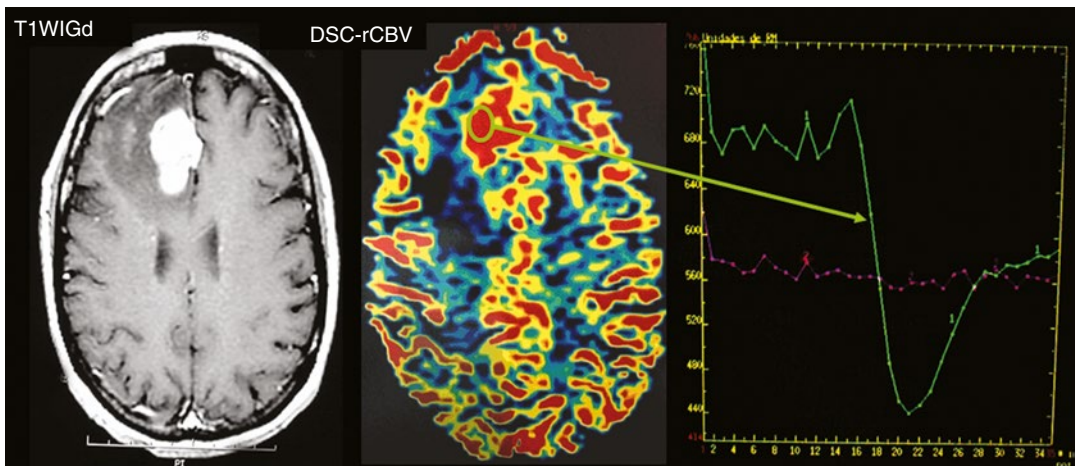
A 52-year-old woman with oligodendroglioma. An expansive-enhancing right frontal lesion with high perfusion (increased rCBV on DSC-MRI) is seen
